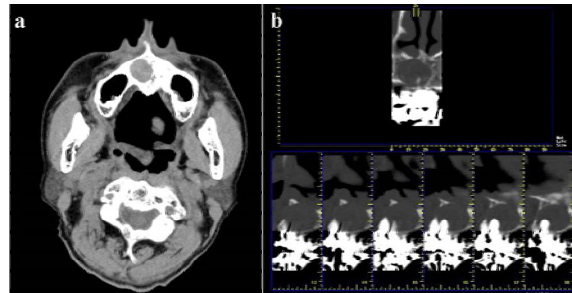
CT images showed a well-defined round lesion including a uniform soft tissue density mass.
